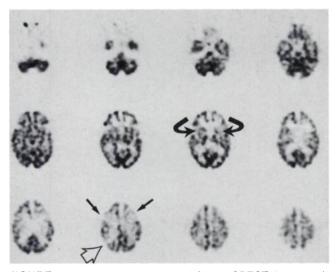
Technetium-99m-HMPAO brain SPECT shows moderate to severely decreased radiotracer uptake in the mid and posterior aspects of the frontal lobes (straight arrows). There is markedly decreased uptake in the basal ganglia especially in the caudate nuclei bilaterally (curved arrows). Decreased uptake is also noted in the superior and posterior portion of the right parietal lobe (open arrow).
